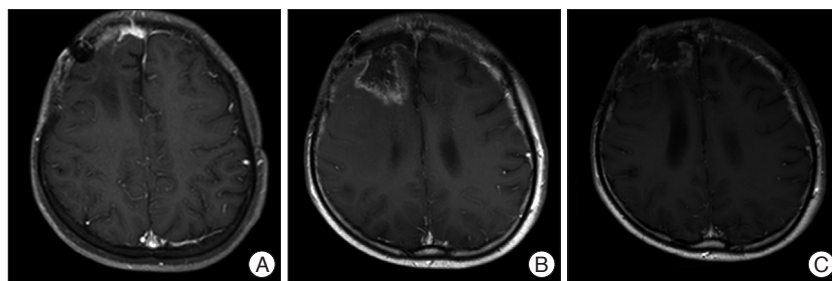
Brain MRI, fourth months after second operation (A), six months after third operation (B), and 13 months after third operation (C). A : T1-weighted post-contrast image reveals localized enhancing mass at right anterior frontal convexity and pachymeningeal enhancement at right frontal area. B : A lesion in the size of 3.0×4.0 cm is found at right frontal lobe, which had unclear boundaries, shows peripheral irregular enhancement, and is accompanied by central necrosis. C : As the size of irregular enhancing lesion is found to be smaller than previous one, it is assumed that this lesion is a result of radiation injury rather than tumor recurrence.
